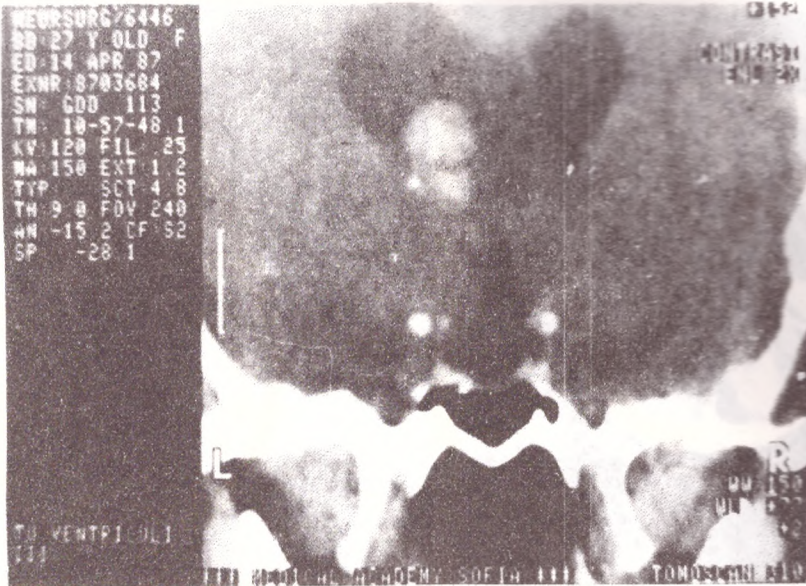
CT scan coronal reconstruction in the same case as Fig. 6-A
